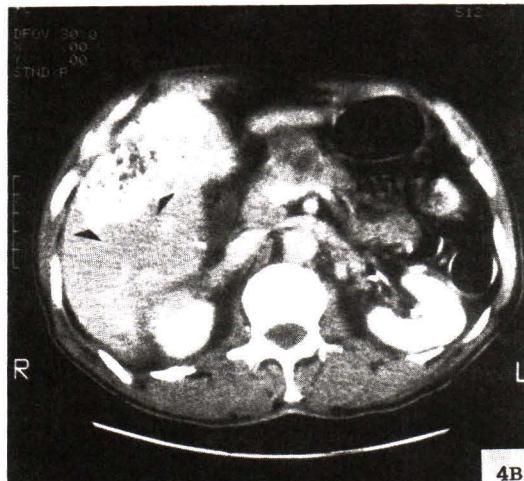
Lipiodol CT scan of the same liver shown in Fig. 4 A taken 2 weeks after TOCE reveals heterogenous accumulation of lipiodol in right lobe liver (arrow head).
